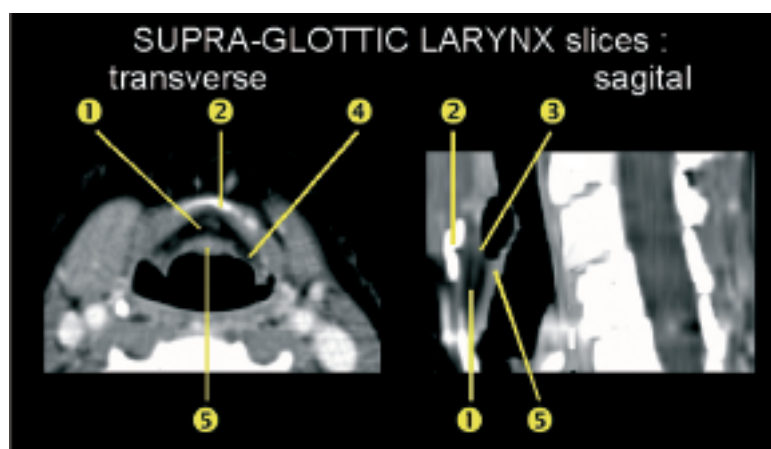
Normal anatomy of the supraglottic region on CT slices. (1) Preepiglottic space. (2) Hyoid bone. (3) Hyoepiglottic membrane, separating the caudal preepiglottic space from the cranial valleculae. (4) Paraglottic space. (5) Epiglottis.
